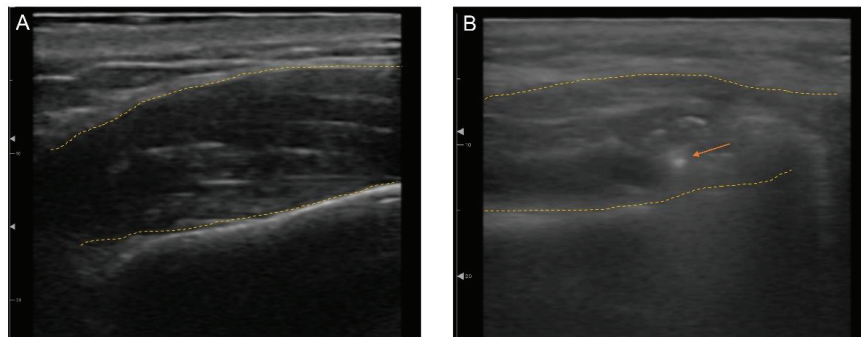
Ultrasonography imaging with outline of the muscle (yellow dotted line) (A) masseter, (B) masseter with needle tip (orange arrow).
